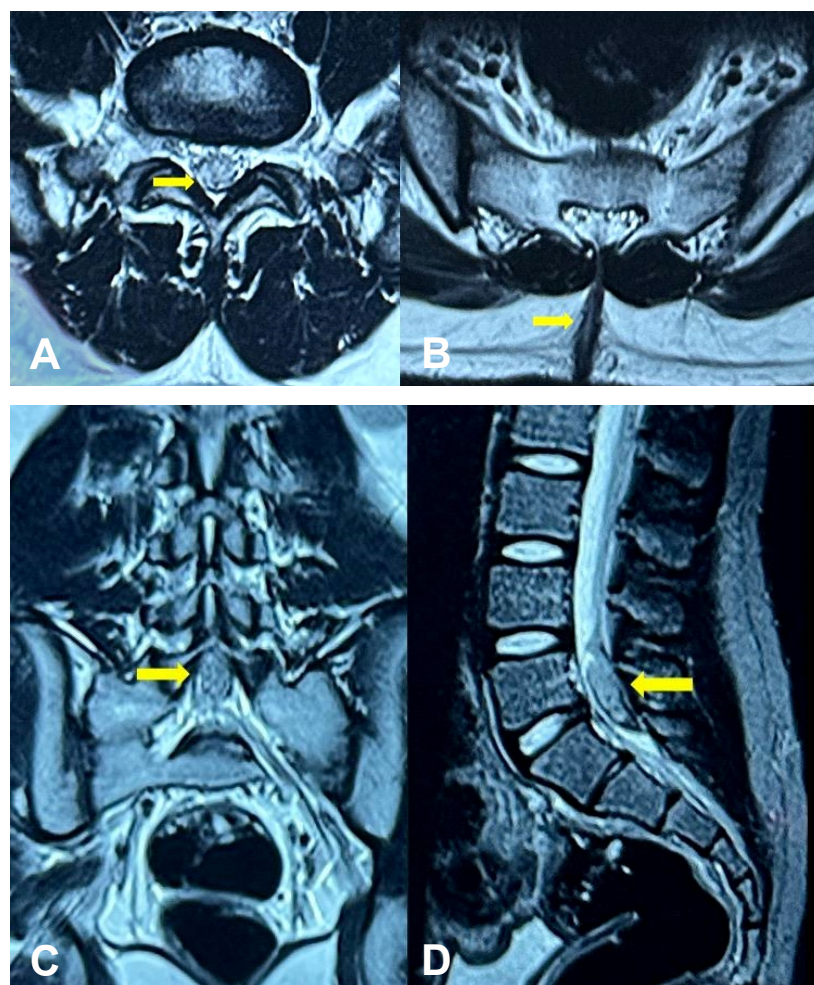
Contrast-enhanced lumbosacral spine MRI
